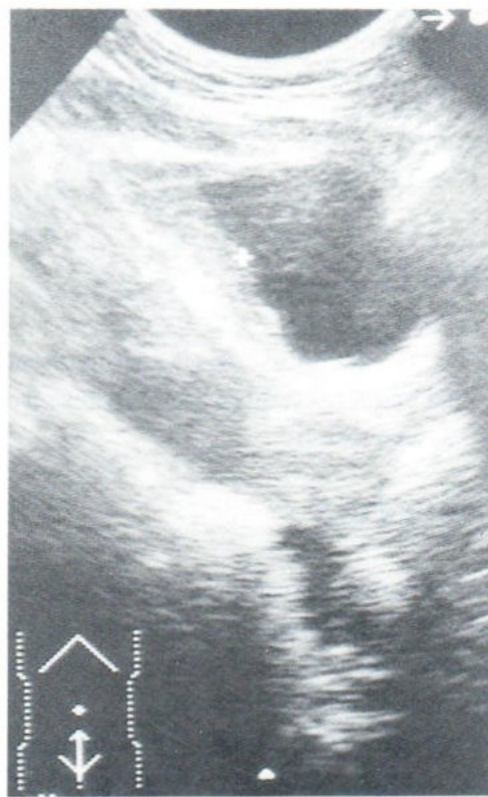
Sagittal ultrasound shows a fixed undulating plaque at the bladder dome.
